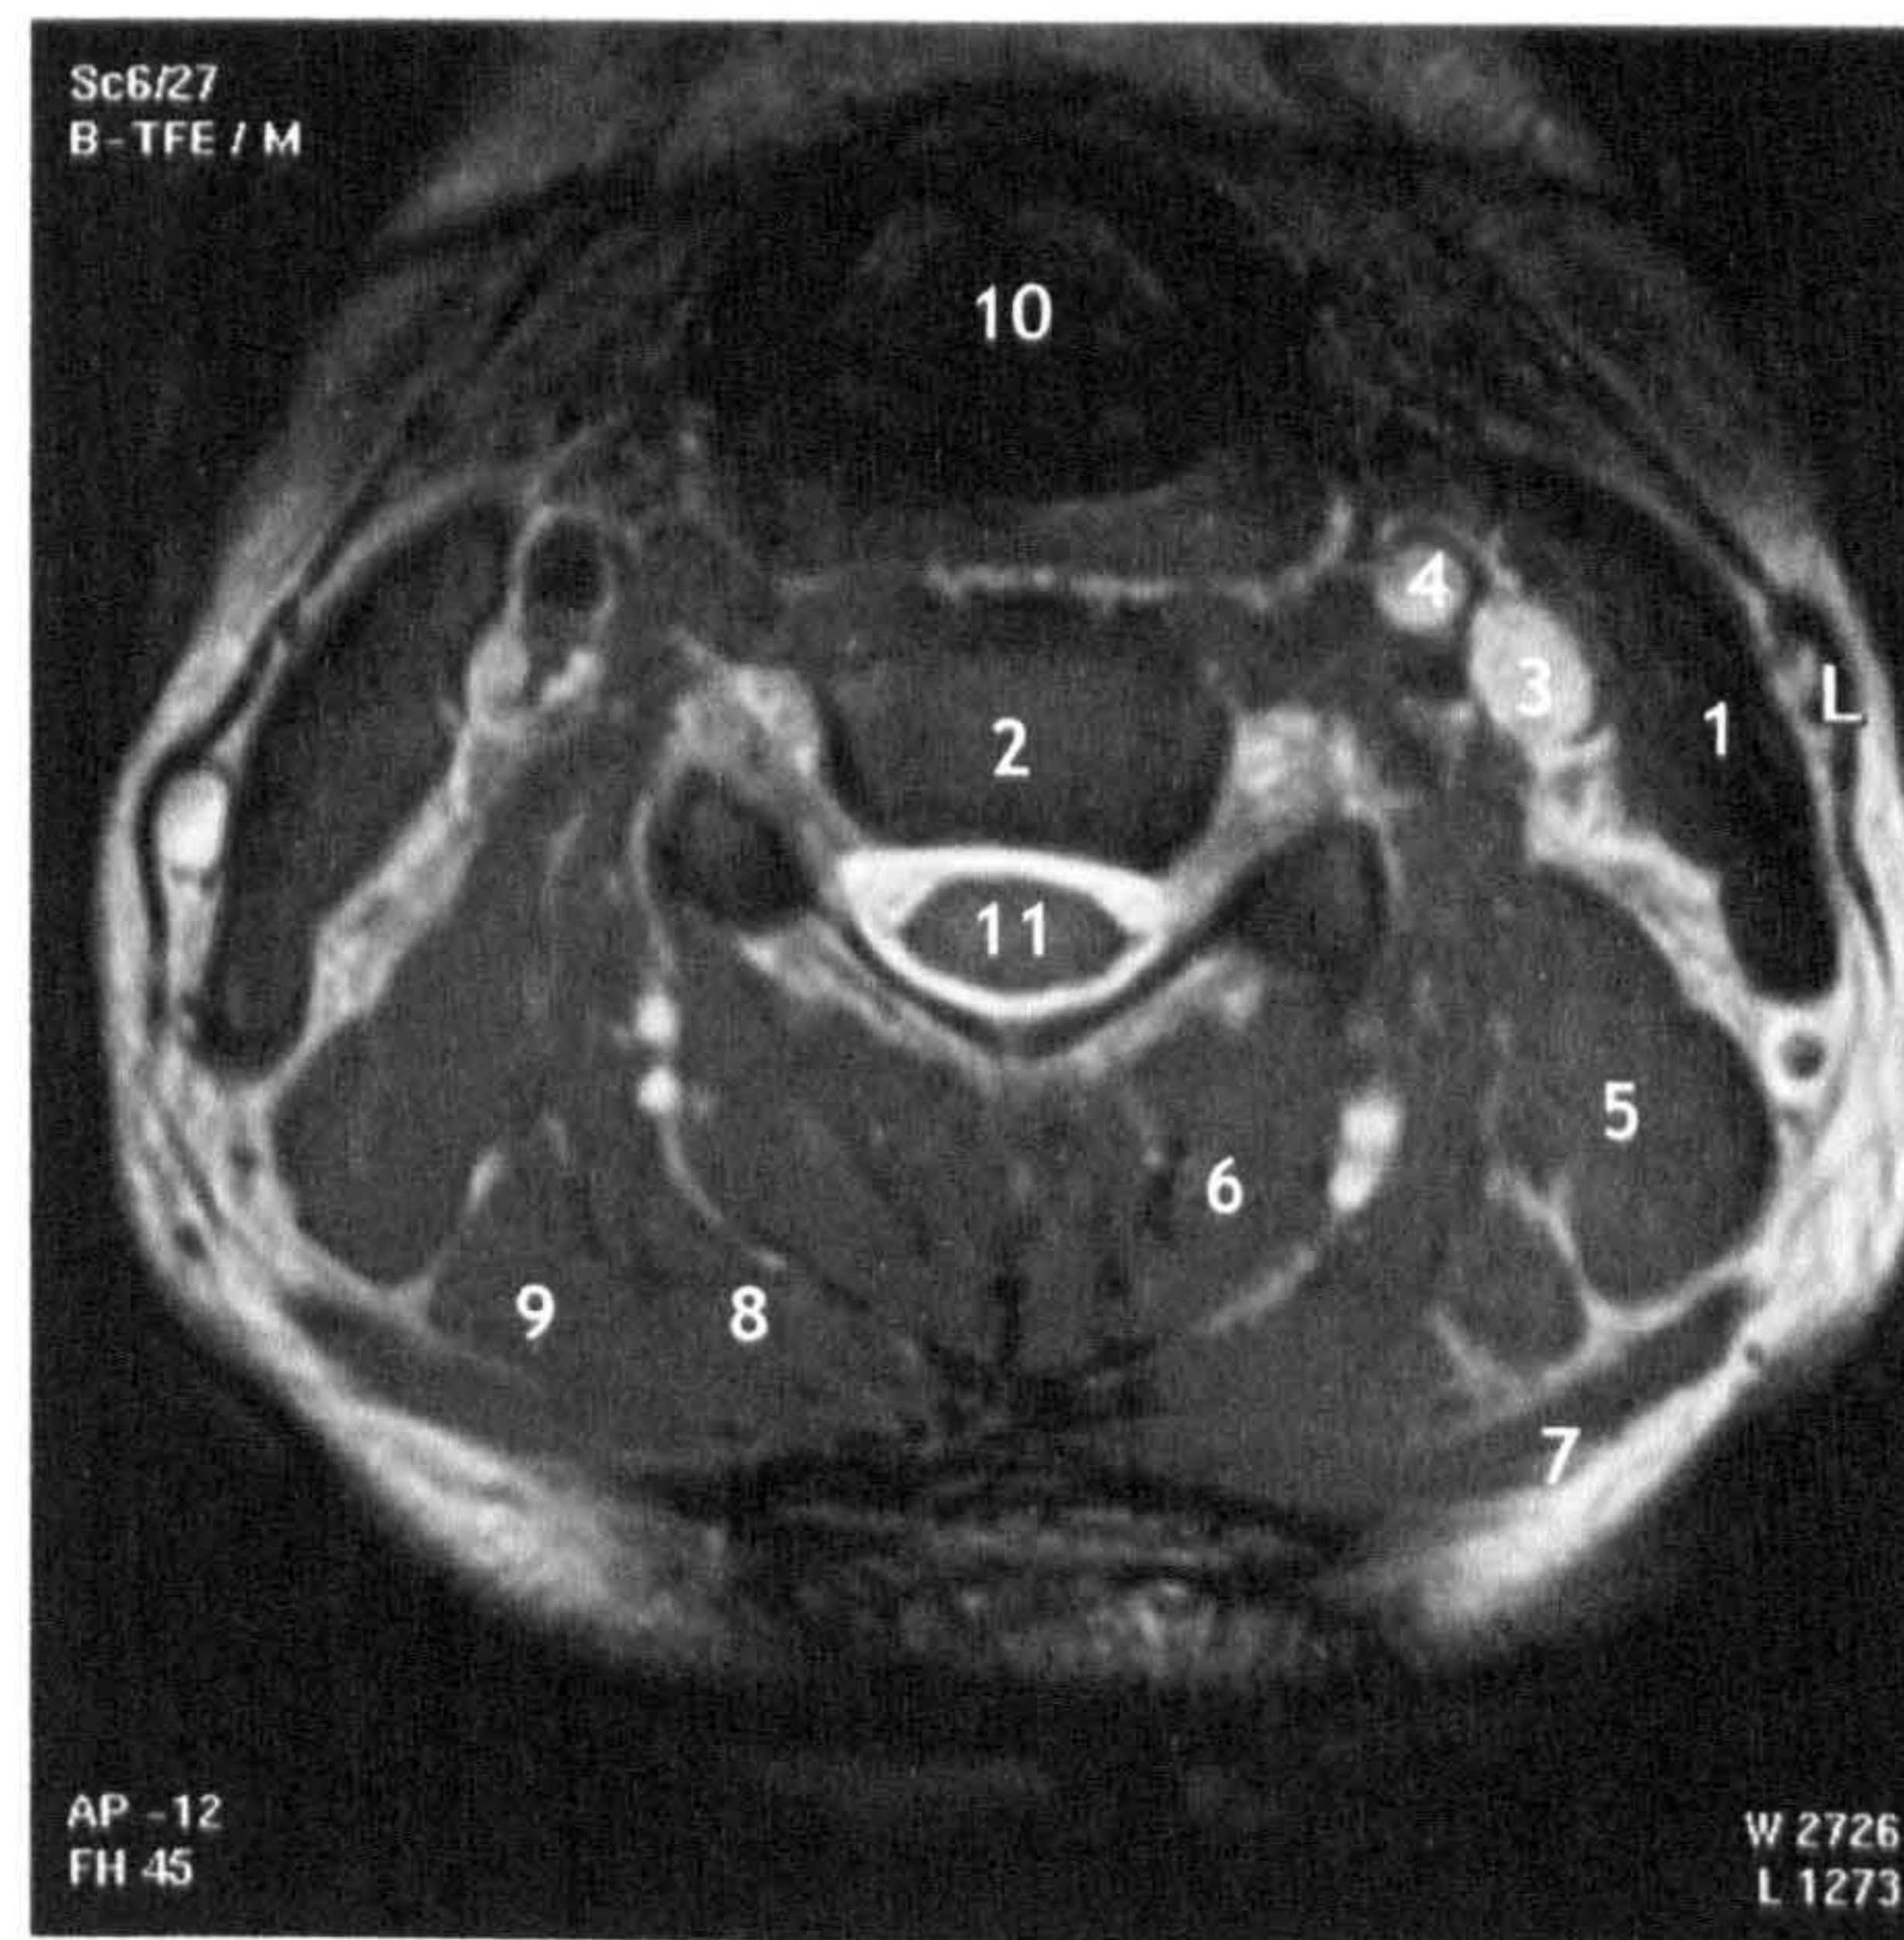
Magnetic Resonance Imaging of the neck
